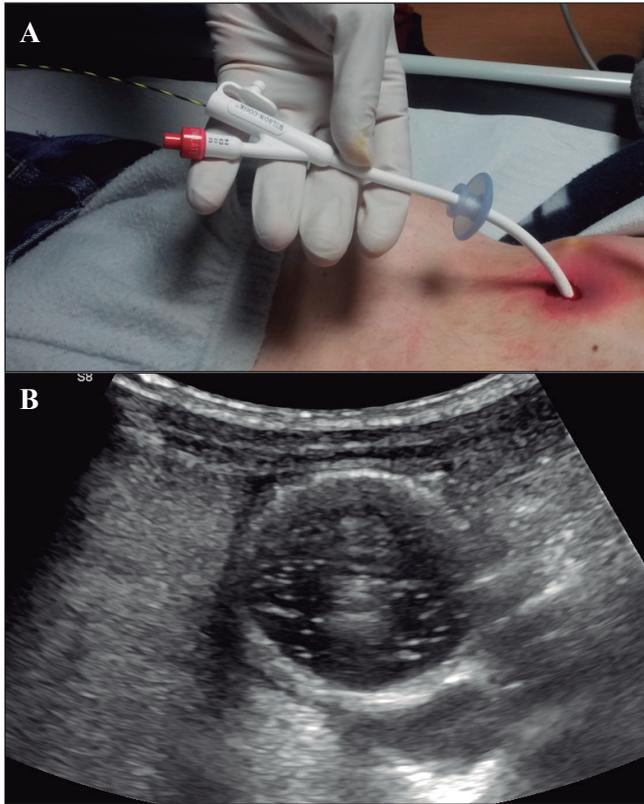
A. Adequate placement of the balloon-tube. B. Ultrasound imaging showing the insufflation of the balloon.
